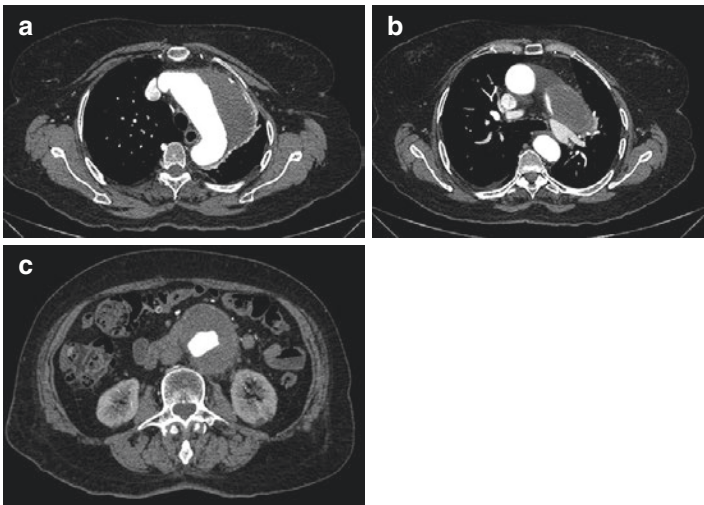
(a) Contrast chest CT showing an enlarged aortic arch with mural thrombus. (b) Contrast chest CT showing non-enlarged ascending aorta. (c) Abdominal contrast CT showing an abdominal aortic aneurysm with mural thrombus
